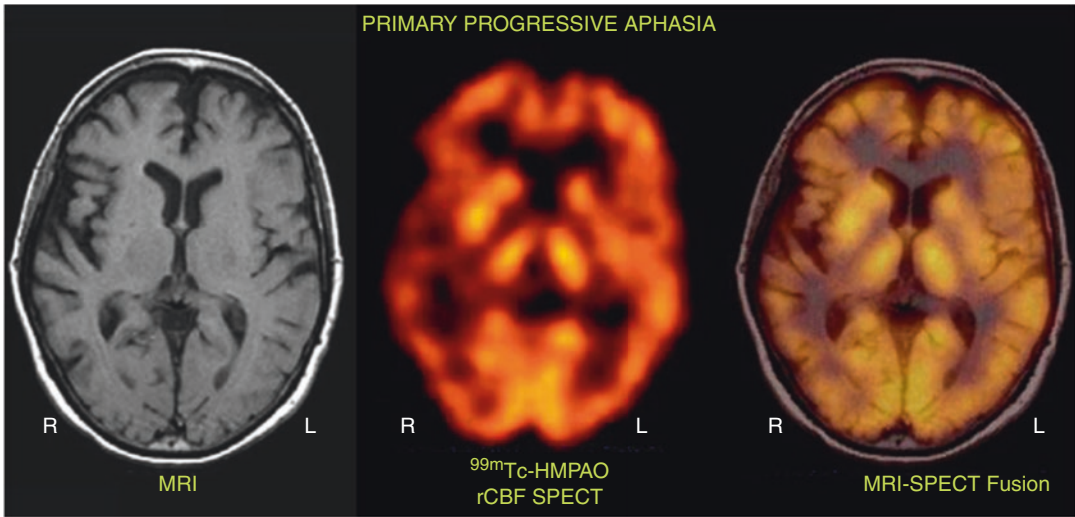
MRI scan (*left*), ^{99m}Tc -HMPAO brain SPECT scan (*middle*), and a MRI–SPECT fusion image (*right*) of a 65-year-old female with a mild degree of dysnomia. The subject presented with a 7-year history of “tripping” over words. She initially had trouble with multisyllable words but currently has difficulty even with single-syllable words. The images show right frontotemporal atrophy on MRI. The SPECT scan, however, shows a much larger
